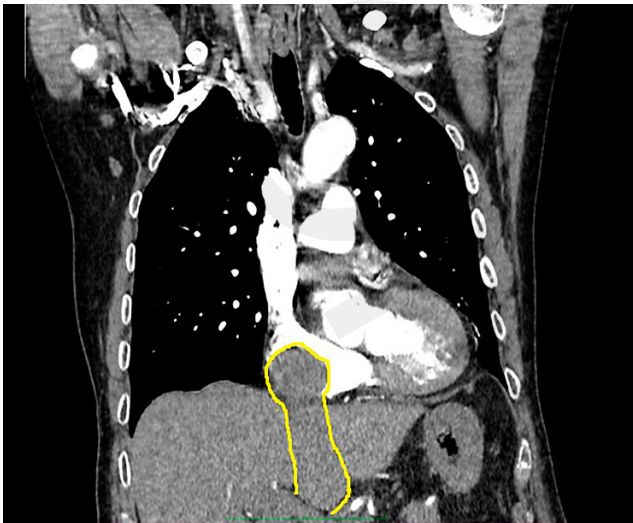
CT angiography of the pulmonary arteries with visible right atrial tumour thrombus (yellow contour)
